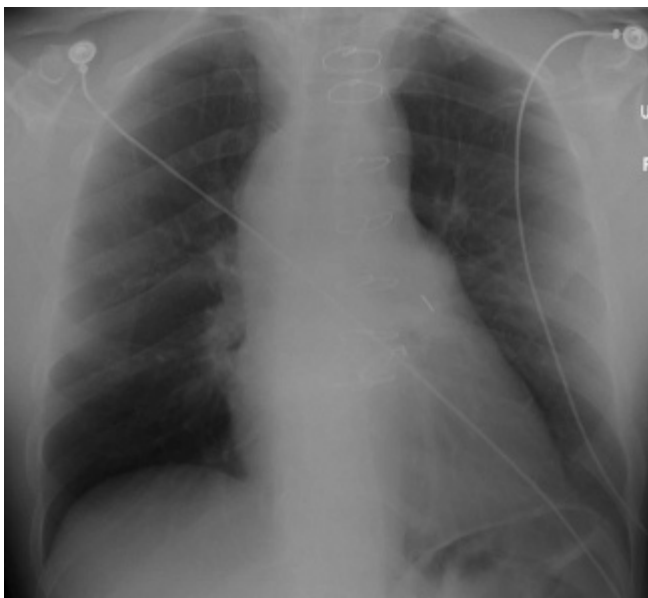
A portable chest radiograph showing a widened superior mediastinum.
